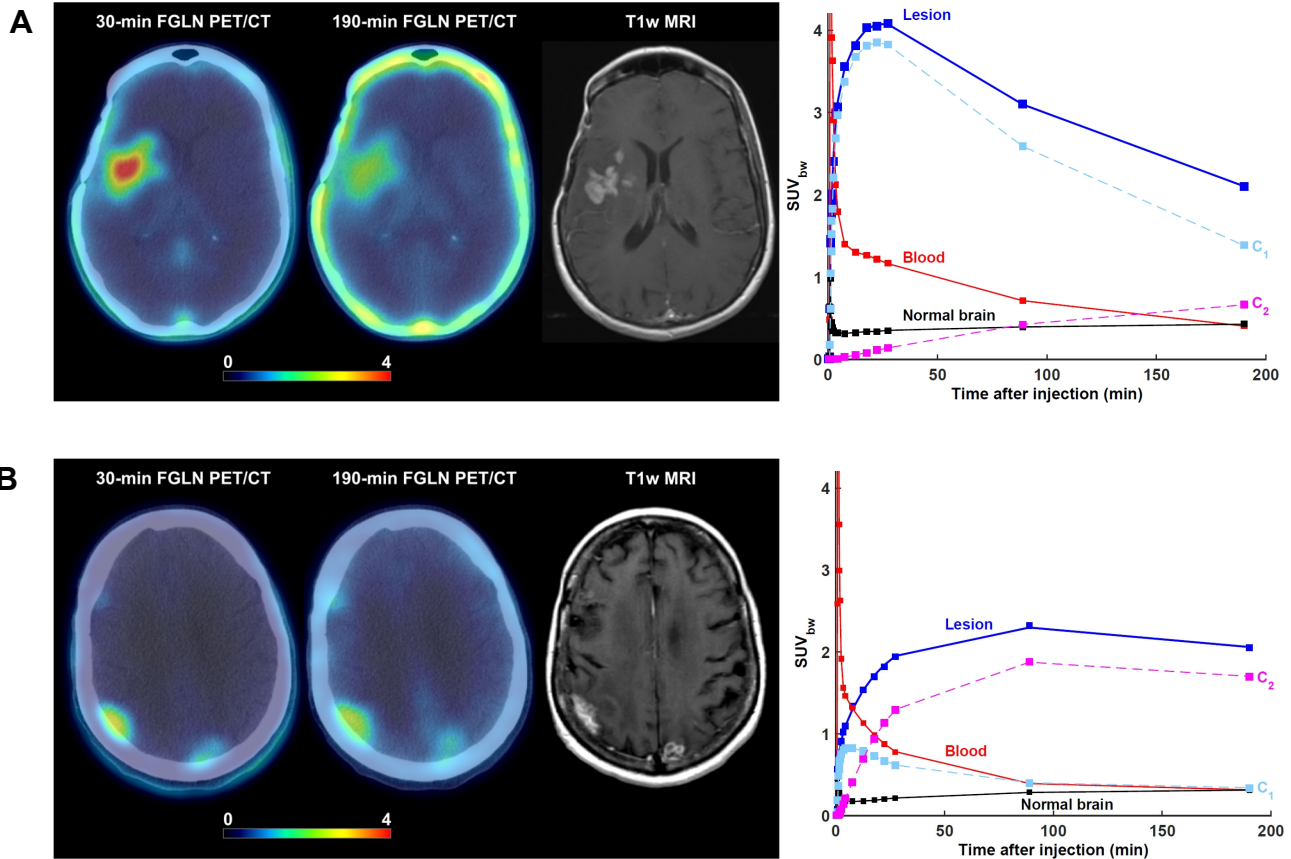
Lesions from two patients exhibiting different ^{18}F -FGln pharmacokinetics despite having very similar SUV_{bw} as measured at 190 min post-injection. In both cases, axial view of the last dynamic PET frame (5-min acquisition time, 25-30 min post-injection) and last imaging frame (\sim 190 min post-injection), fused with corresponding CT is displayed. Post-gadolinium contrast T1-weighted MRI is included for comparison. Three time-activity curves (TACs) shown are for whole tumor (blue); image-derived input function scaled by the whole-blood activity concentration as measured from blood samples, patient-specific plasma fraction, and population-based metabolite fraction (red); and normal brain tissue (black). Contributions to the total PET signal for tumor TACs are superimposed in light blue (first compartment; C_1) and purple (second compartment; C_2). (A) 52-year-old female patient with confirmed diagnosis of astrocytoma. ^{18}F -FGln PET/CT shows the 2 cm^3 lesion in the right frontotemporal region. Mean intratumor K_1 , k_2 , k_3 , k_4 , and V_T were 0.28 $\text{mL}/\text{min}/\text{g}$, 0.08 min^{-1} , 0.002 min^{-1} , 0.001 min^{-1} , and 3.9 mL/cm^3 , respectively. Corresponding values for normal brain tissue were 0.02 $\text{mL}/\text{min}/\text{g}$, 0.09 min^{-1} , 0.001 min^{-1} , 0.001 min^{-1} , and 0.5 mL/cm^3 , respectively. SUV_{bw} at 30 min, 90 min, and 190 min was 4.0, 3.1, and 2.1, respectively. At
